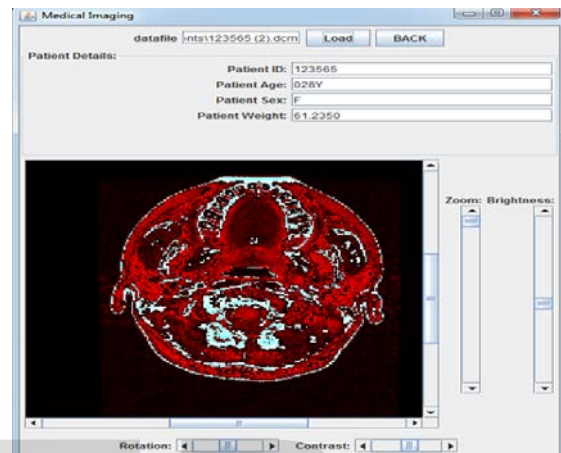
Retrieval of patient info from MRI scan
